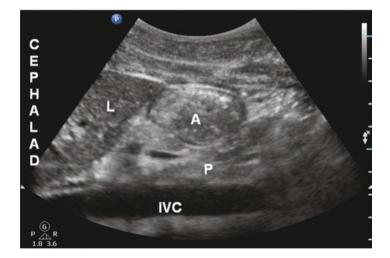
Sonographic image of the gastric antrum with solid meal content. A antrum, L liver, P pancreas, *IVC* inferior vena cava. Reproduced with permission from Van de Putte and Perlas (2014)
